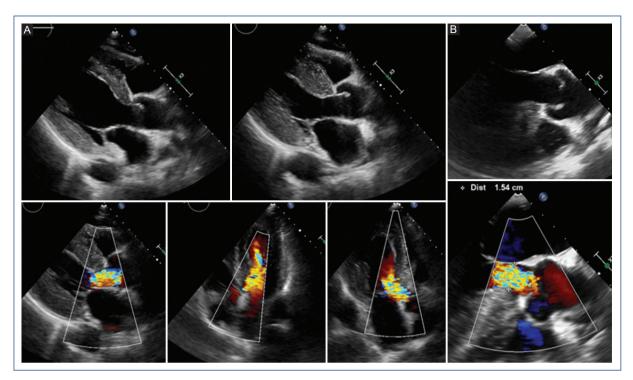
A: transthoracic and B: transesophageal echocardiogram showing severe concentric LVH of up to 23-25 mm with involvement of the right ventricle, with a nondilated the left ventricle and normal biventricular systolic function, as well as significant aortic regurgitation due to rheumatic involvement of the aortic valve.
